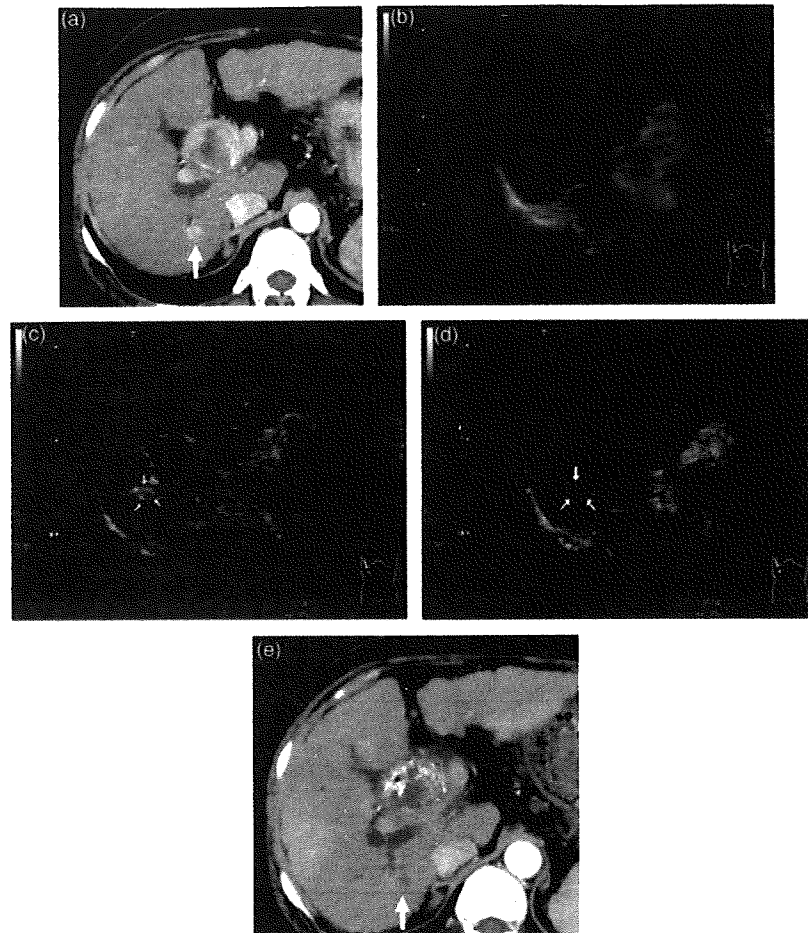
Fifty-seven-year-old female, hepatitis B virus-related liver cirrhosis. (a) Contrast-enhanced computed tomography (CT) image. A hypervascular lesion (arrow) considered to be hepatocellular carcinoma was demonstrated on CT image. (b) Non-contrast sonogram. Hepatic lesion corresponding to CT findings was not recognized on the sonogram before enhancement. (c) Contrast-enhanced sonogram in the early phase. A hypervascular lesion was demonstrated on the sonogram after enhancement (arrows). (d) Contrast-enhanced sonogram in the late phase. The lesion showed negative enhancement in this phase (arrows). (e) Contrast-enhanced CT image after a percutaneous ethanol injection. Hepatic lesion showed a hypovascular appearance after the treatment (arrow).
